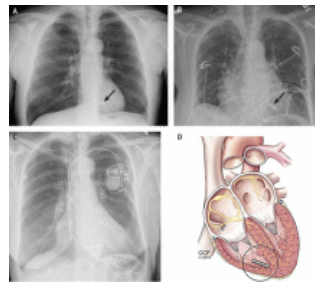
Frontal-plane radiographs showing implanted Nanostim (A) and Micra (B) leadless pacing devices and a traditional dual-chamber pacemaker (C). Panel D depicts cardiac deployment.
